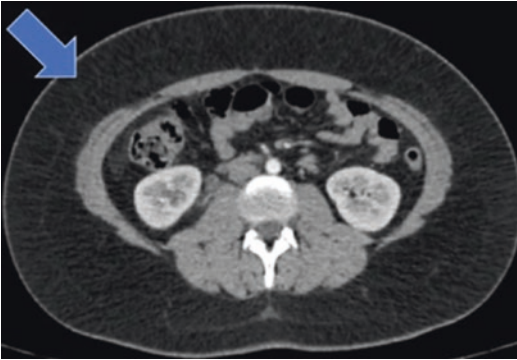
CT image in an obese patient, arrow showing abdominal wall fat content. (From O. Traxer twitter account)
